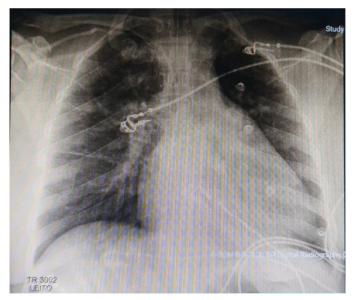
Chest X-ray upon arrival at the Intensive Care Unit.
